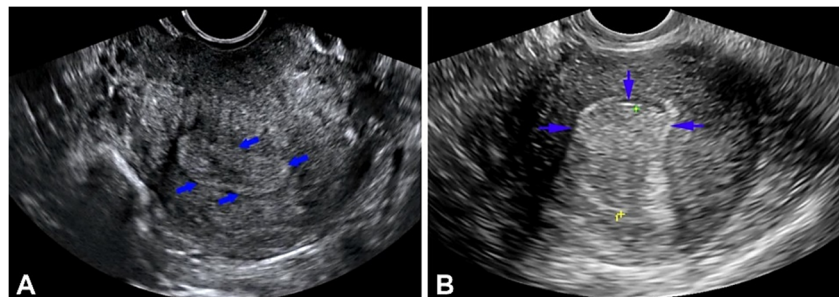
Transvaginal ultrasound demonstrating EP: (A) EP appearing as a hyperechoic image with uniform outlines inside the uterine cavity (green arrows) and cystic spaces within the polyp (red arrows); (B) EP – cystic areas are observed inside the polyp. EP: Endometrial polyp.
